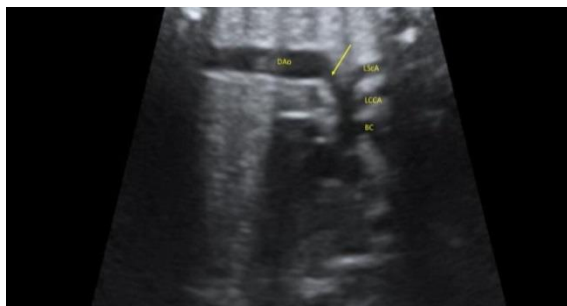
Ultrasound image of CoA with the dorsal approach. Arrows point to aortic isthmus and coarctation. LScA: Left subclavian artery; LCCA: Left common carotid artery; BC: Brachiocephalic artery; DAo: Descending aorta.
